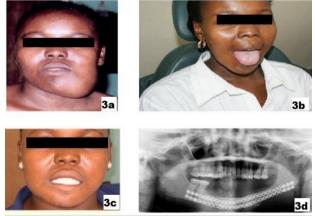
a) Large ameloblastoma in the left horizontal ramus of the mandible extending into the symphysis. Four years postoperatively she has restored symmetry of the mandible and was able to stick out her tongue. b) & c) She had no problems swallowing. d) The radiograph shows excellent healing of the bone graft that measured more than 15 mm.
